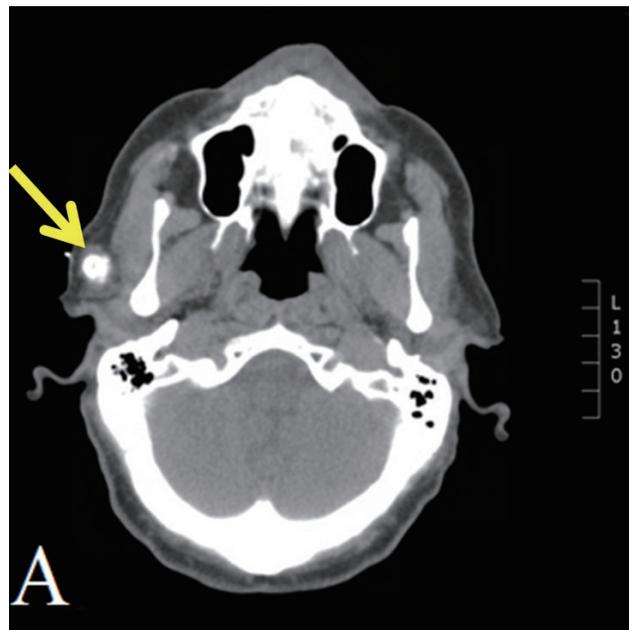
CT scan imaging of the head showing a calcified mass measuring 1.4 cm × 1.5 cm × 1.6 cm in the superior aspect of right parotid gland with no involvement of the adjacent bony structures (A, arrow)
